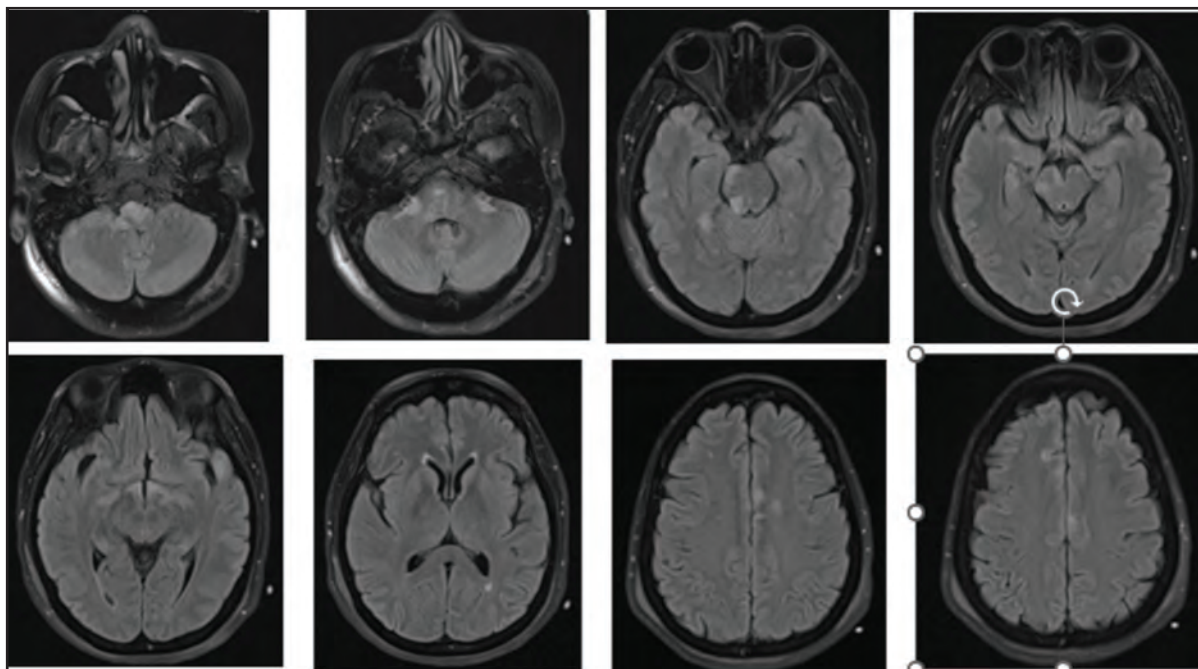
Axial FLAIR brain images showed patchy hyperintensities at medulla (A), bilateral cerebellar peduncles (B), pons (C), midbrain (D), third ventricle and hypothalamus (E), peritrigonal region (F), parasagittal bifrontal cortex (G) & (H)
